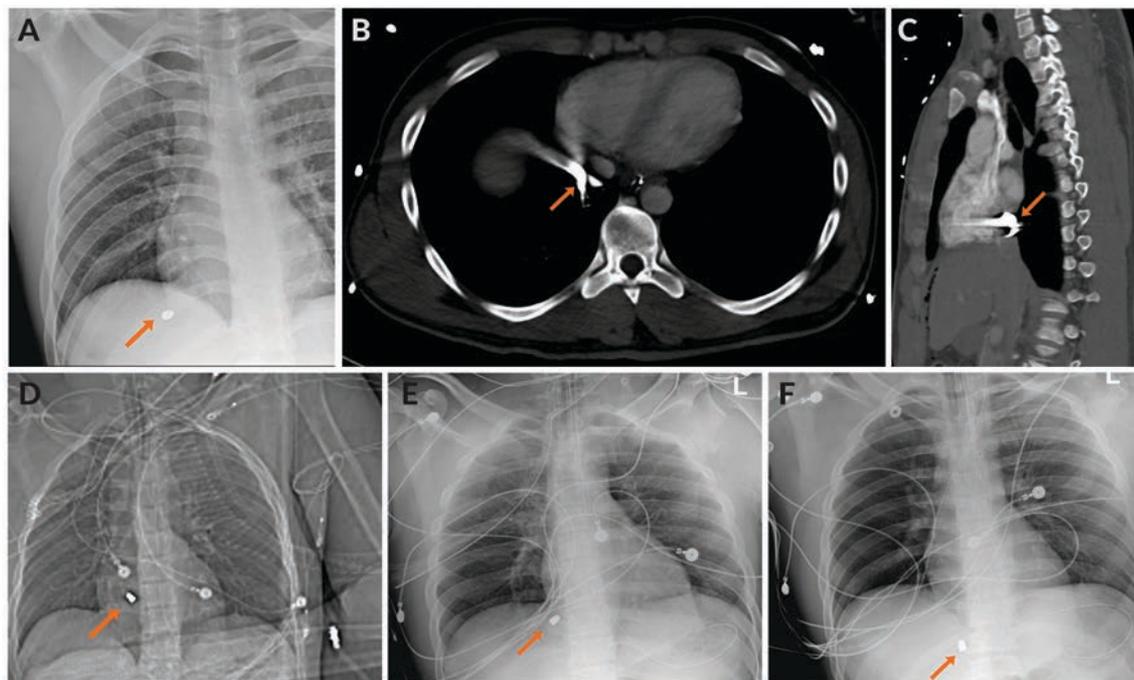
On presentation, a chest radiograph showed a metallic ballistic object projecting over the high right upper quadrant of the abdomen below the right hemidiaphragm (A). Following exploratory laparotomy during which the bullet was not found in the abdomen, computed tomography images suggested an intravascular location at the inferior cavoatrial junction on axial (B), sagittal (C), and scout (D) images. Preprocedural portable chest radiographs taken hours apart also suggested fragment mobility (E-F).
